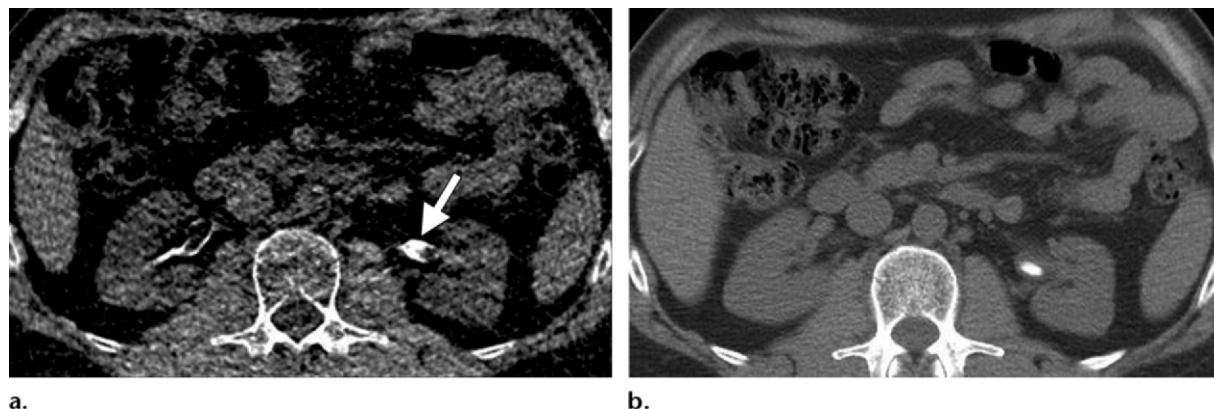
(a) Axial water-density (virtual unenhanced) image from excretory-phase dual-energy CT urography shows a bright rim around both urinary collecting systems, an artifact that limits their visual evaluation. A focal area of hyperdensity in the left renal collecting system (arrow) might represent either an artifact or a calculus. Incomplete subtraction of iodine-containing pixels from the renal collecting systems, ureters, and bladder during the reconstruction of virtual unenhanced images may lead to both false-positive and false-negative findings of calculi. (b) Axial unenhanced conventional CT image helps confirm the presence of a 1-cm calculus in the left renal pelvis.
